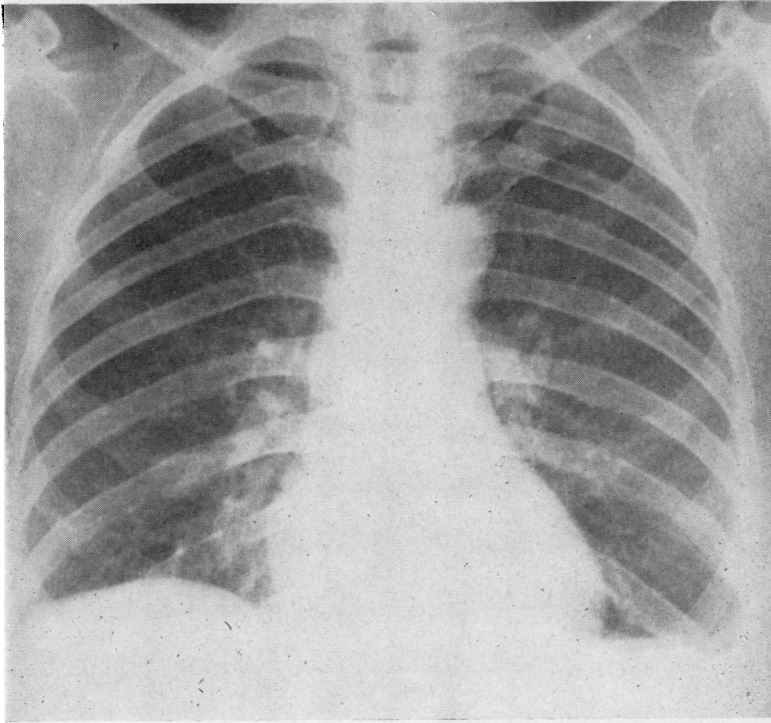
Case 2. Radiograph taken four days after that shown in Fig. 2 reveals a decrease in pulmonary infiltration and less pleural fluid.*
